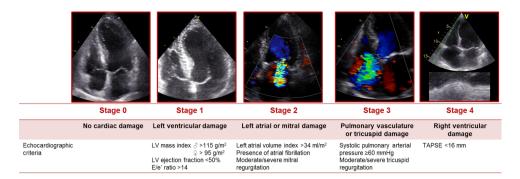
Stages of cardiac damage in severe AS. Proposed staging classification based on the extent of echocardiographic signs of extra-aortic valvular cardiac damage. AS, aortic stenosis; LA, left atrial; LV, left ventricular; TAPSE, tricuspid annular plane systolic excursion.
